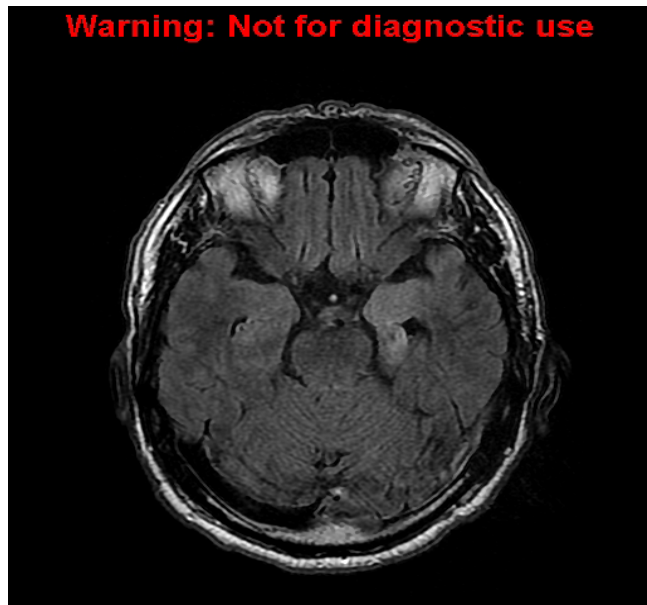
Axial FLAIR MR image of the brain shows the high signal intensity of the left medial temporal lobe.
